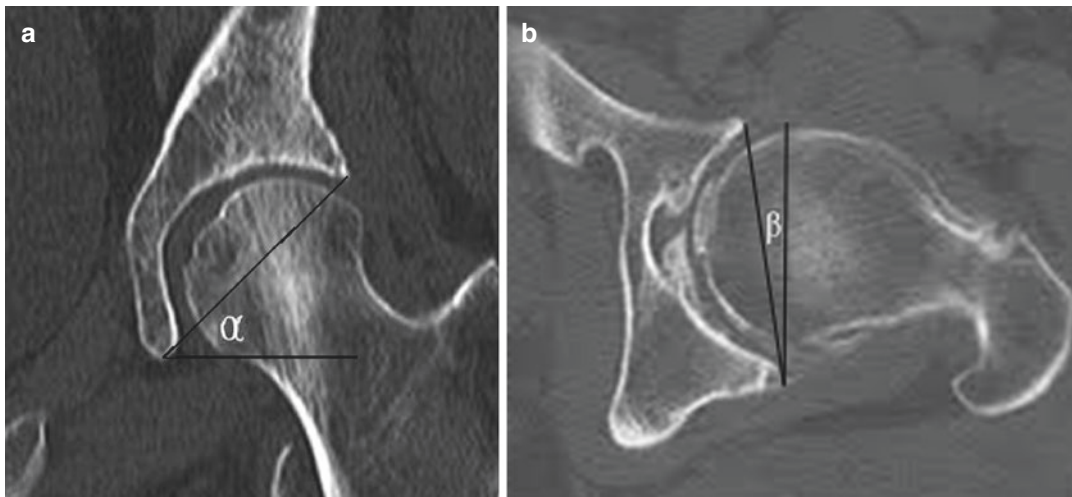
(a) Acetabular abduction angle (α) is measured on a mid-coronal CT image. (b) Acetabular anteversion angle (β) is measured on a mid-axial CT image
